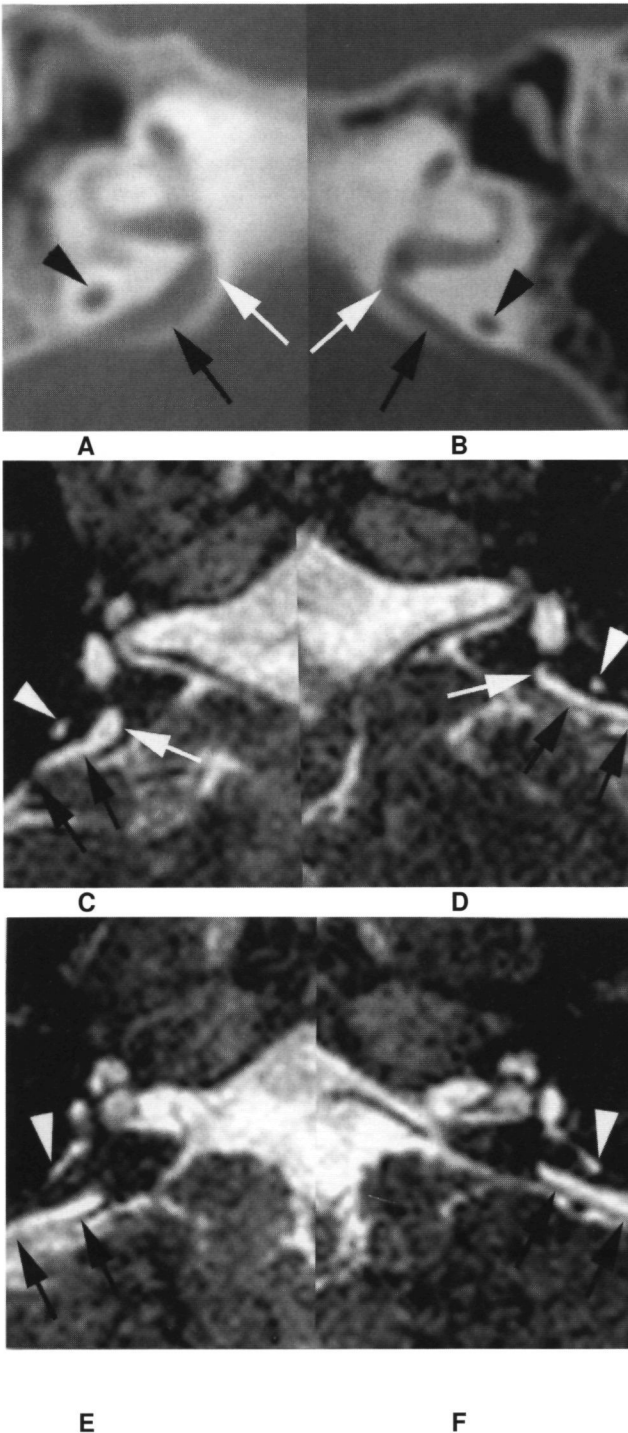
Images obtained from patient VI-8 showing unilateral large vestibular aqueduct on CT scan, bilateral enlarged endolymphatic duct/sac on MRI study. Axial CT images (A,B) and axial three-dimensional Fourier transformation-constructive interference in steady-state MRI scan (C,D) at the level of the ascending part and inferior part (E,F) of the posterior semicircular canal (PSC) of the right (A,C,E) and left (B,D,F) inner ear. A,B. The right vestibular aqueduct is enlarged (large arrows), and its diameter is clearly larger than that of the PSC (black arrowhead). The diameter of the left vestibular aqueduct (large arrows) is similar to that of the PSC and is therefore not enlarged but borderline. Notice the fusion of the head of the malleus with the corpus of the incus on both sides. Bilateral narrowing of the ampulla of the lateral semicircular canal can be seen. C,D. The right endolymphatic duct (white arrow) and sac (black arrows) have a longer diameter than the posterior semicircular duct (white arrowhead). The diameter of the left endolymphatic duct (white arrow) and sac (black arrows) are equal to or smaller than the diameter of the posterior semicircular duct (white arrowhead) and is therefore borderline/normal. E,F The right endolymphatic sac (black arrows) is larger in diameter than the right posterior semicircular duct (white arrowhead). At this level, it also becomes obvious that the left endolymphatic sac (black arrows) is larger in diameter than the left posterior semicircular duct (white arrowhead). The endolymphatic sac is easier to recognize on the MRI scan because it can be distinguished from the cerebrospinal fluid in the posterior fossa by the dura mater, which separates both fluid-containing structures. Notice the hypoplasia of the modiolus in the left and right cochlea.
